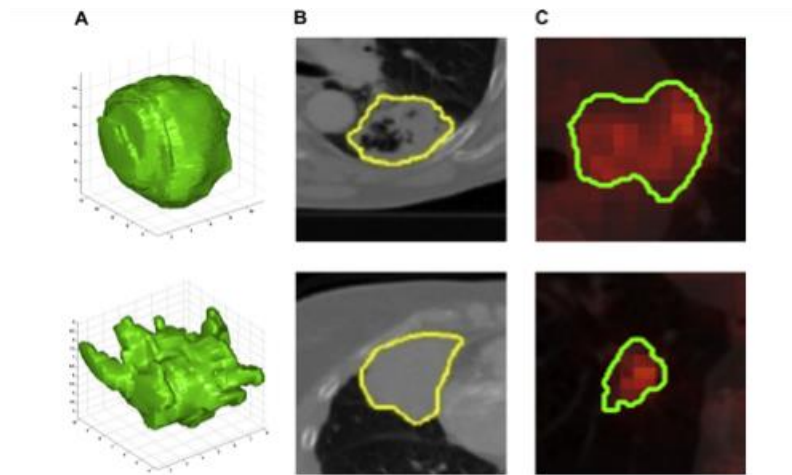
Tumor segmentation. A, two representative 3-D representations of a round tumour (top) and spiky tumour (bottom) measured by computed tomography (CT) imaging. B, Texture differences between non-small cell lung cancer (NSCLC) tumours measured using CT [20]
